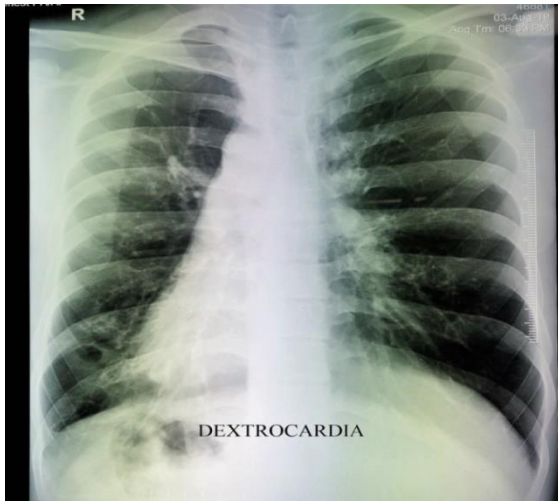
xray showing dextrocardia
